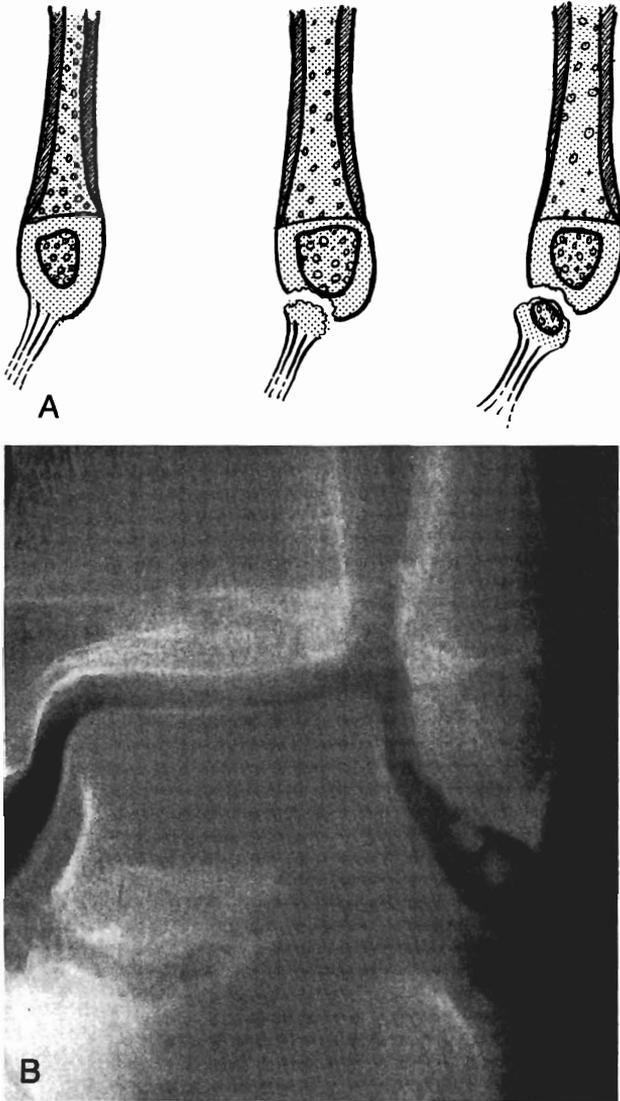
(A) When a ligament is avulsed with a fragment of preosseous cartilage, the initial radiograph is normal. (B) After a month an ossicle becomes obvious.
